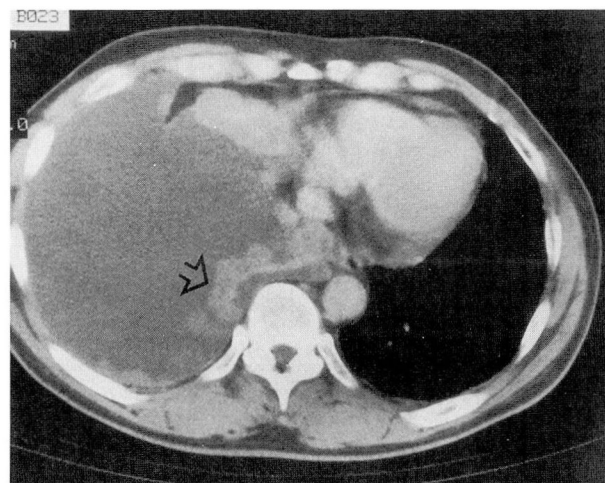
Thoracic computed tomographic scan showing the presence of pleural masses. Upon biopsy, these proved to be malignant.
